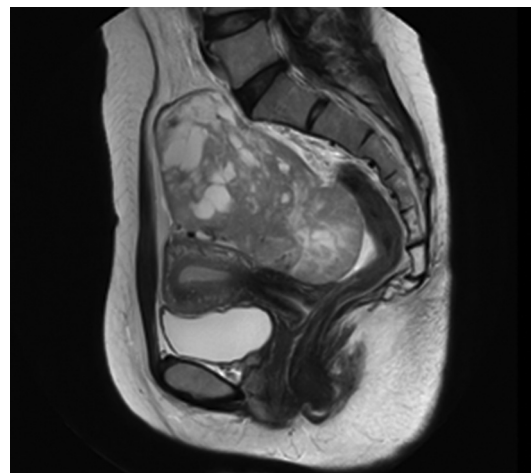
Magnetic resonance imaging result (T2)
